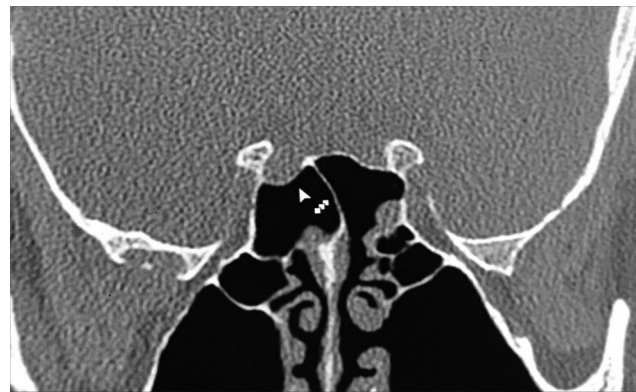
Coronal CT image of a 50-year-old male showing type II Delano's classification of optic nerve relation to the sphenoid sinus.
